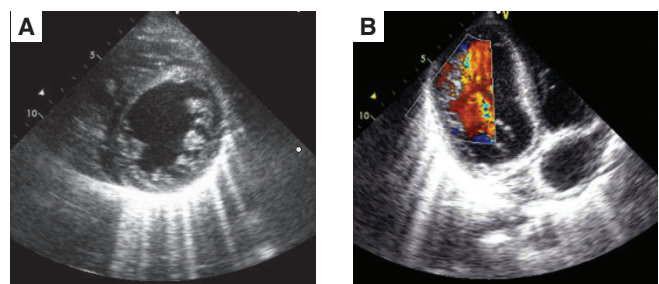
A: increased left ventricular trabeculation B: colour Doppler showing blood flow between the trabeculations.
